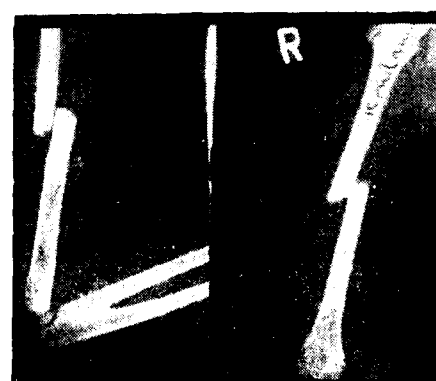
X-ray showing transverse fracture of the humerus above the deltoid insertion.
